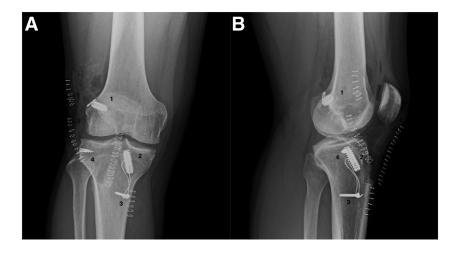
Anteroposterior (A) and lateral (B) radiograph after anterior cruciate ligament reconstruction using bone—patellar tendon—bone autograft and LET showing the graft fixed into the femoral (1) and tibial (2) tunnels using metal screws; double tibial fixation to a post (3); LET using a double suture anchor (4). (LET, lateral extra-articular tenodesis.)
